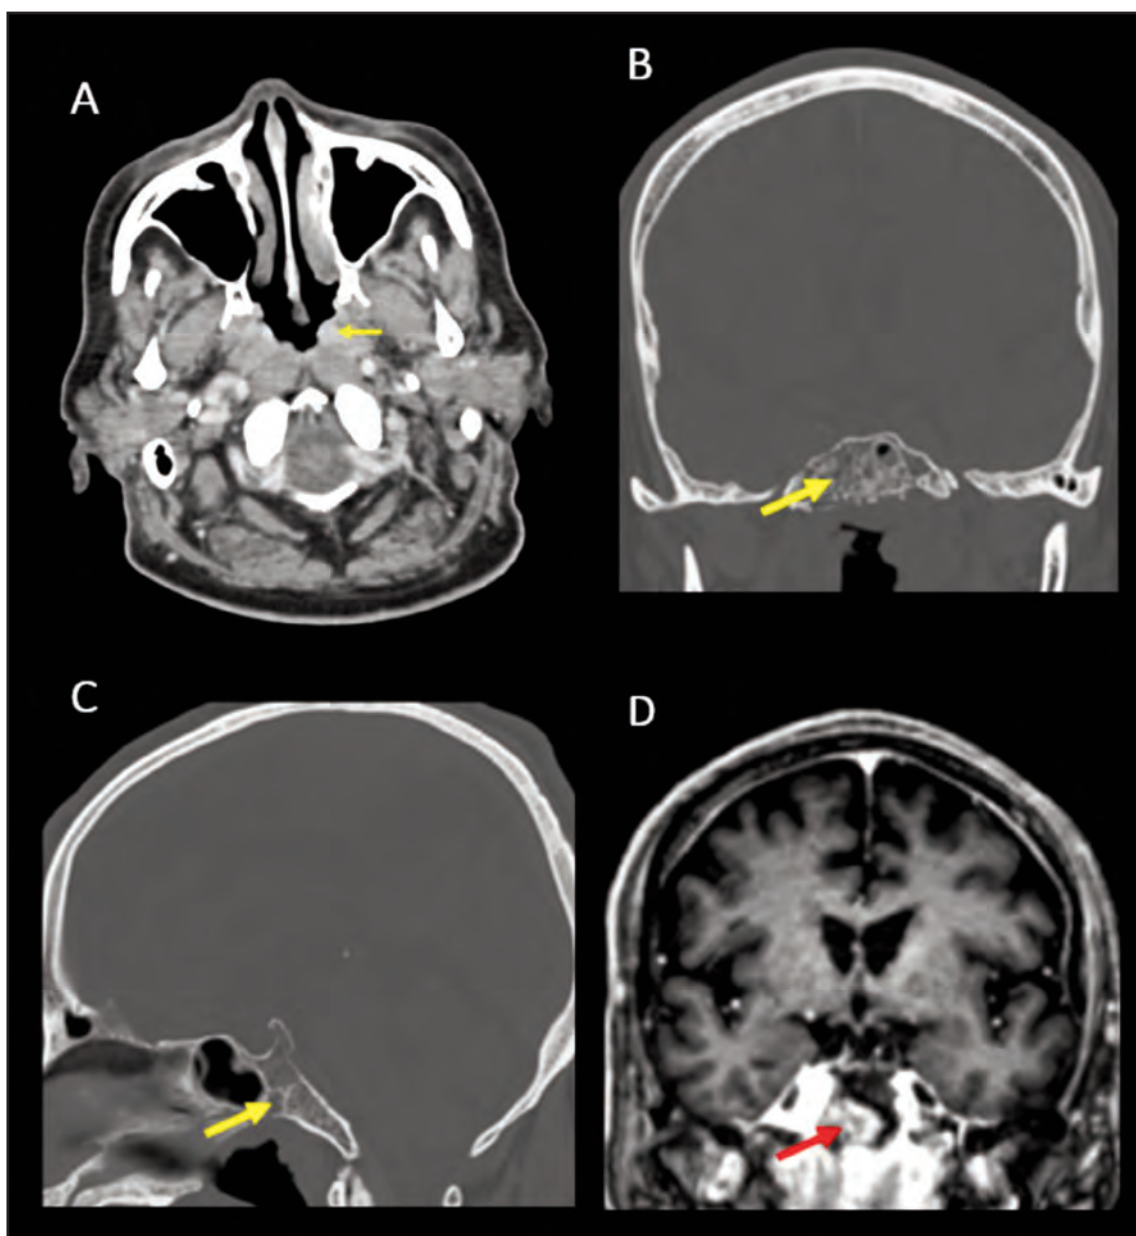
Contrast-enhanced CT neck and MRI Brain. (A) A sub-centimeter enhancing mass at the left torus tubarius (yellow arrow), consistent with the primary tumour of NPC. CT Brain in bone window in coronal view (B), sagittal view (C), reveal bony erosion of the sphenoid bone (yellow arrow), sparing the clivus. (D) Contrast enhanced MRI of the brain in coronal view showed an enhancing mass (red arrow) within the bony erosion, extending towards the right cavernous sinus while sparing the left cavernous sinus
